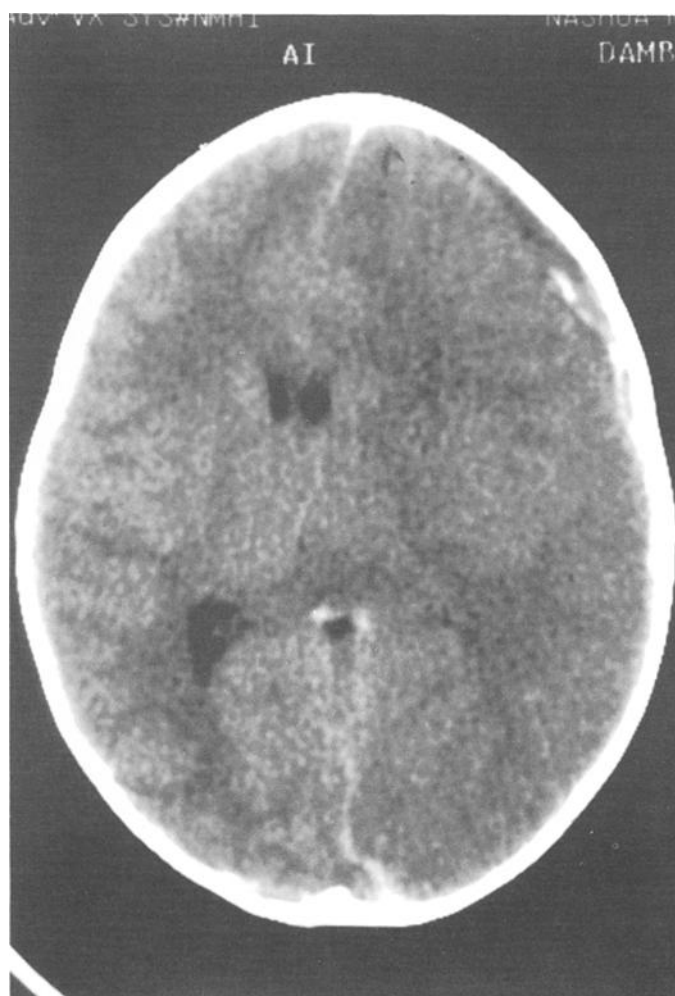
CT scan on day of admission revealing mixed density left parietal convexity subdural hematoma with left hemisphere edema and mass effect.
